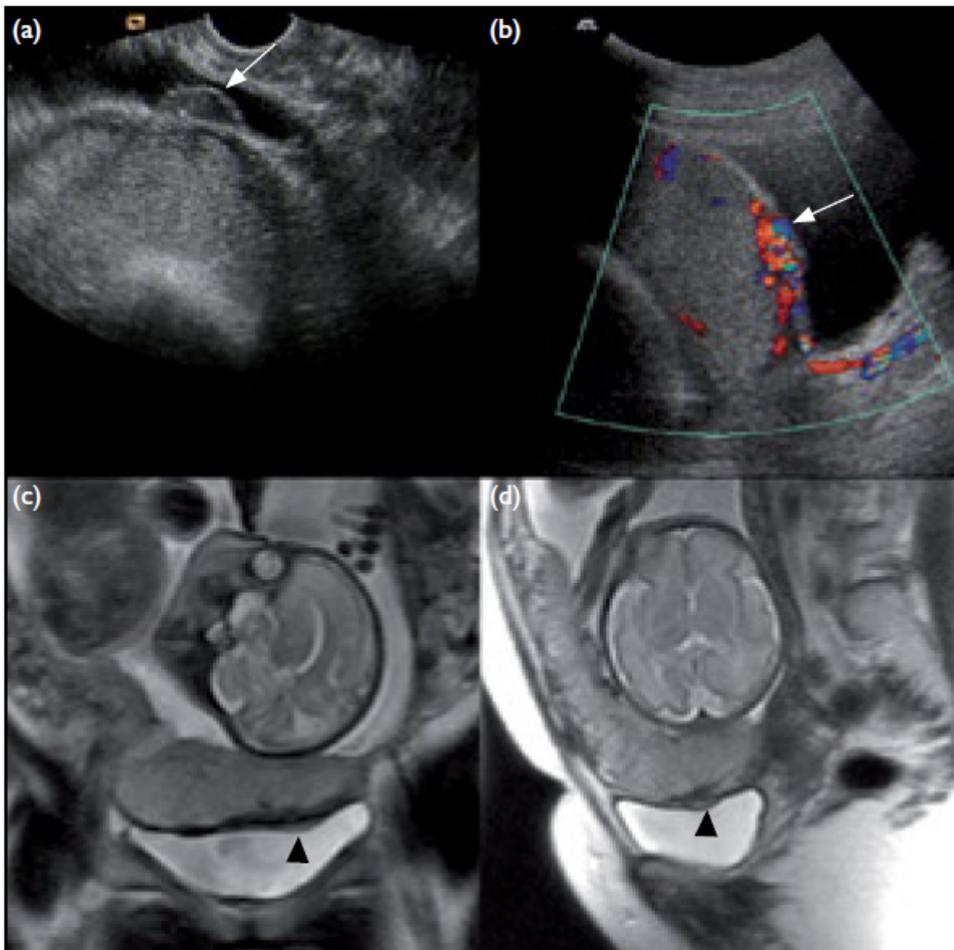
Placenta praevia with morbidly adherent placenta: (a,b) Transvaginal sonographic images revealing no myometrial tissue between the lower uterine wall and the bladder. There is also an abnormal vessel running within the bladder wall (white arrows). Corresponding (c) coronal and (d) sagittal magnetic resonance images indicate a bulge at the bladder wall (black arrowheads).
